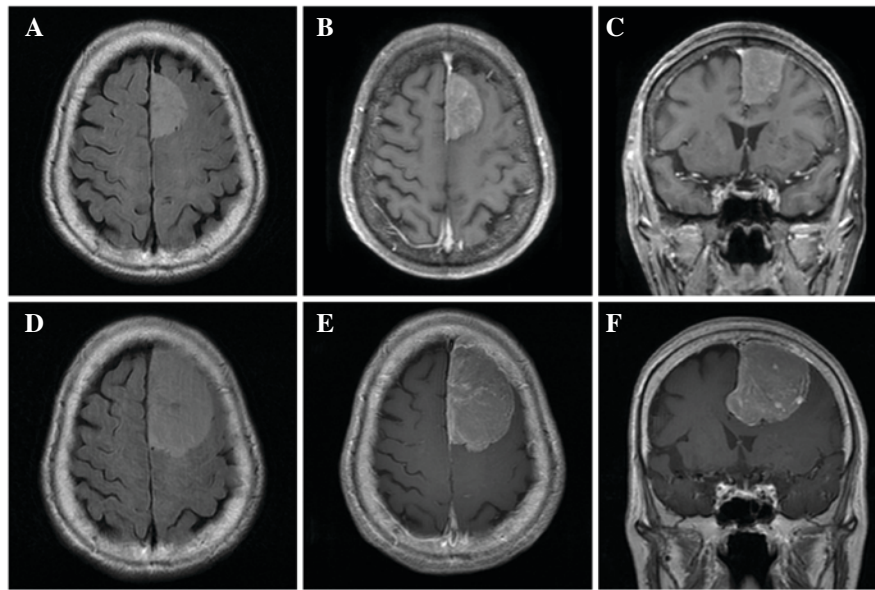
Representative case. (A) Axial fluid-attenuated inversion recovery MRI image and (B) axial and (C) coronal MRI performed at initial examination revealed an enhanced extra-axial mass without peritumoral brain edema. (D) Axial fluid-attenuated inversion recovery MRI image and (E) axial and (F) coronal MRI performed 2 years after diagnosis. MRI revealed evident tumor growth with peritumoral brain edema. MRI, magnetic resonance imaging.
